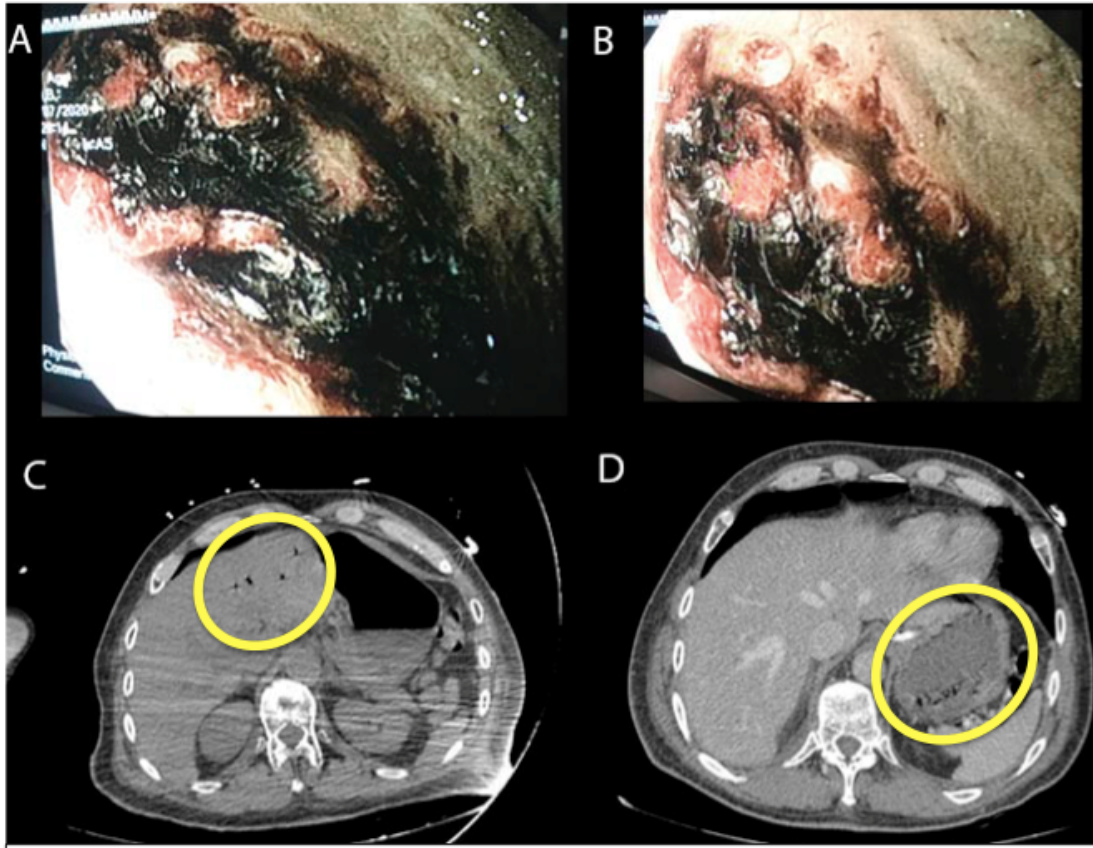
Gastroscopy (A-B): Clearly delimited blackish and necrotic area with surrounding healthy mucosa. Sheet bleeding treated with Hemospray due to extreme friability. Noncontrast abdominal CT scan: We see gas in the portal system, predominantly in the left liver lobe (C) and the wall of the gastric fundus significantly edematous with air bubbles in its thickness (D).
